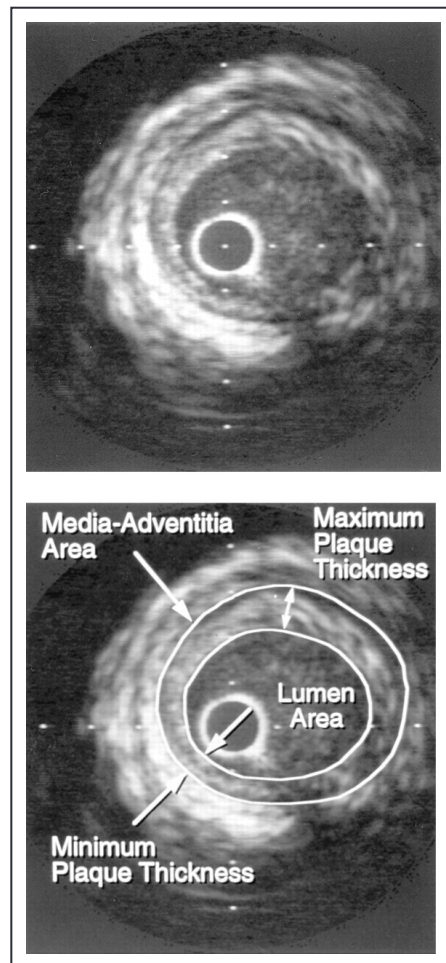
Measurements of lumen and vessel wall dimensions in an ultrasound image.
